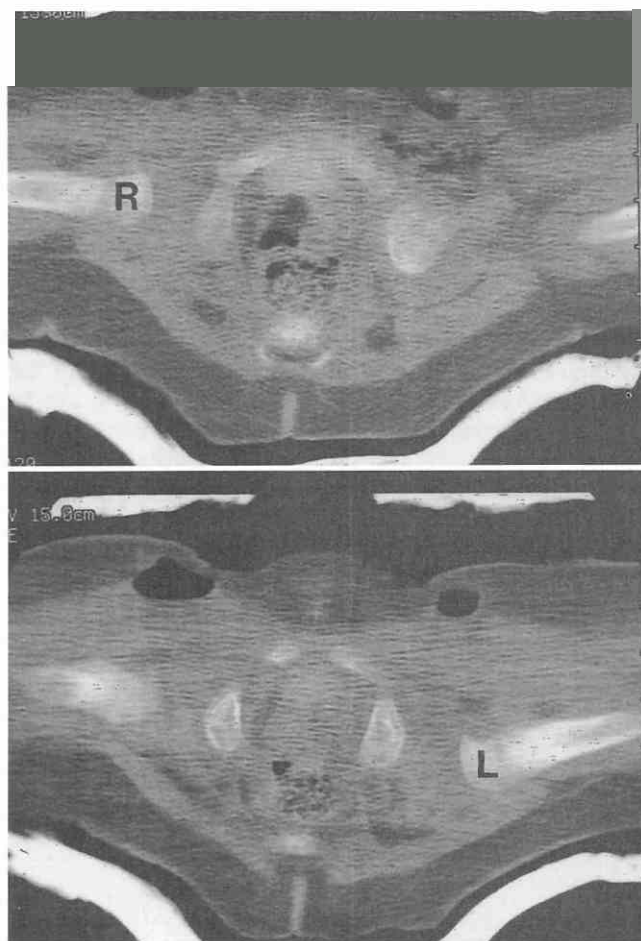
Bilateral developmental dysplasia of the hips in a 2-month-old infant wearing a spica cast. Apart from the scout topogram, these two axial images constituted the entire CT examination. The images were obtained with 40 milliamperes-seconds (mAs). Neither femoral head is ossified. *Top*, Right hip reduced, with the femoral metaphysis (R) in correct alignment with the right acetabulum. *Bottom*, persistent posterior dislocation of the left hip (L).
